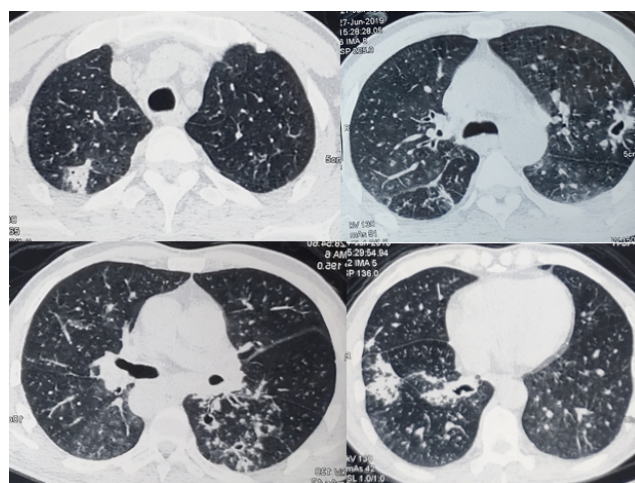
HRCT chest after 10 days of proper antibiotic therapy showing resolving consolidation, cavitory lesion and decreased infiltrations
